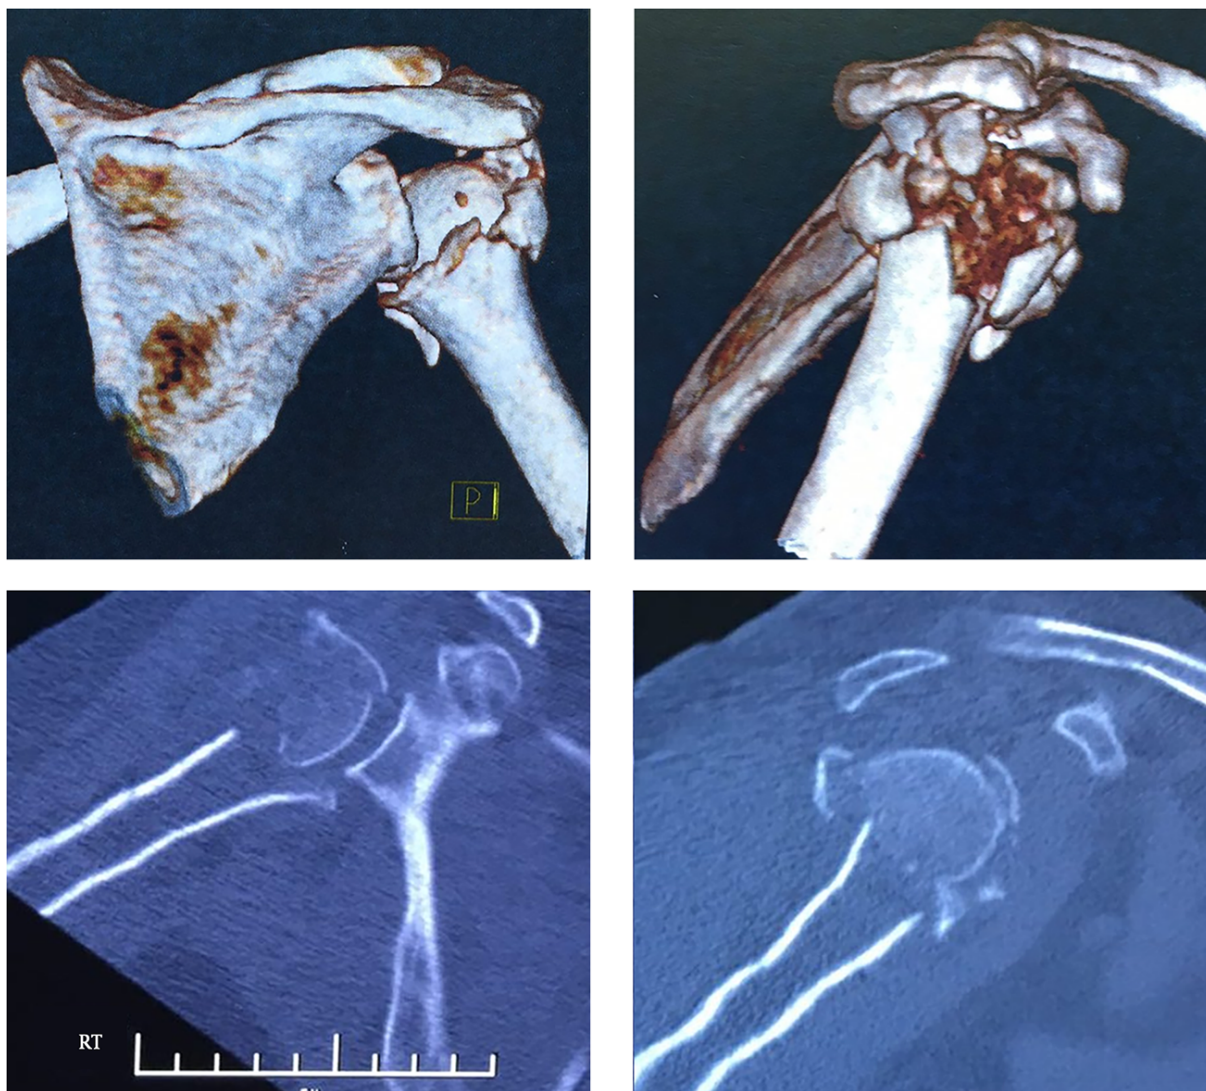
CT scan demonstrates right proximal humeral fracture
